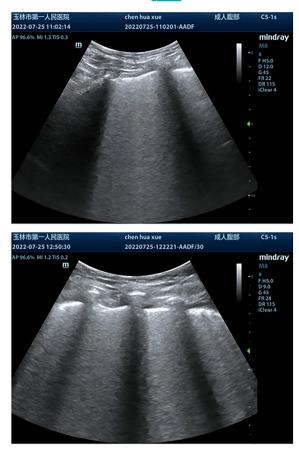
Lung ultrasound imaging prior to initiation of venovenous extracorporeal membrane oxygenation (VV-ECMO).
